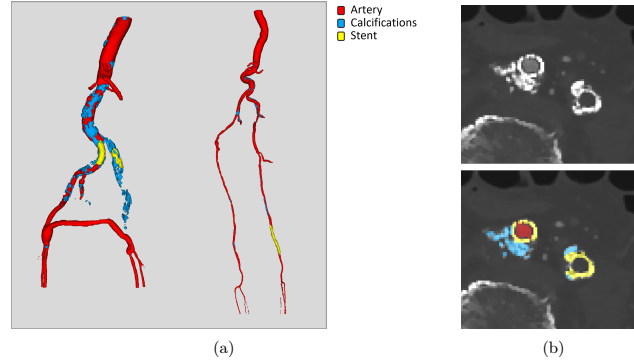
(a) A 3D representation of Artery, Calcification and Stent segmentation. (b) Axial CTA representation with and without segmentation annotations.
